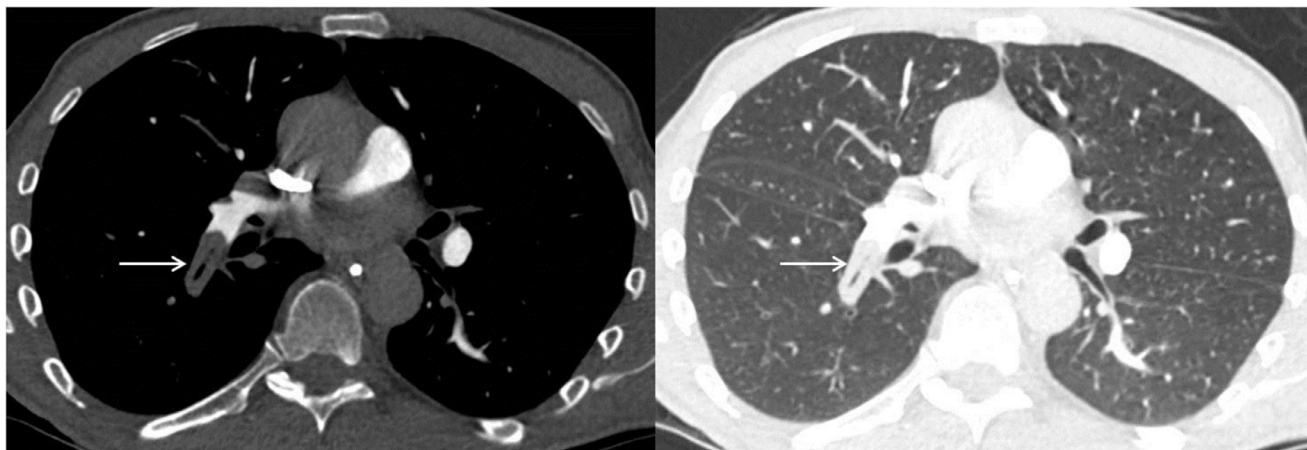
CT pulmonary angiogram in mediastinal and lung windows demonstrates a filling defect in the right lower lobar pulmonary artery with central gas (arrows).
